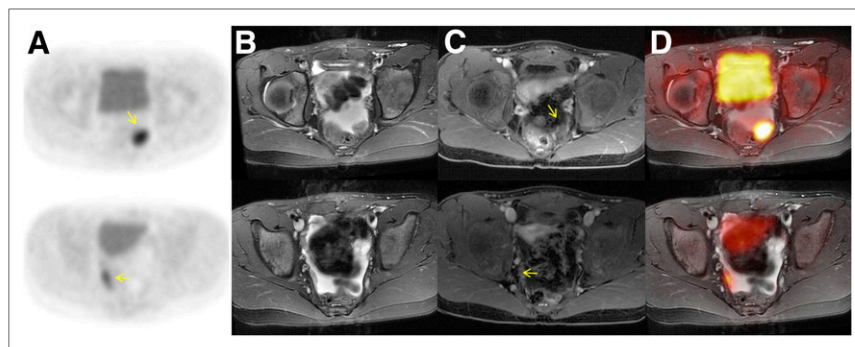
Concordance between ^{18}F -FDG PET avidity and gadolinium chelate enhancement in 10-y-old girl after resection of immature teratoma. (A) ^{18}F -FDG PET image demonstrates 2 foci of marked glucose hypermetabolism in left and right lower pelvis (arrows). (B) T2-weighted MR image shows that these foci correspond to small soft-tissue nodules outlined by pelvic fluid. (C) T1-weighted MR image after contrast administration shows enhancement of these nodules (arrows). (D) T2-weighted PET/MR image shows the nodules amid pelvic fluid.
